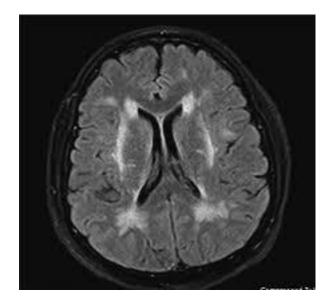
Brain MRI findings in a patient with CADASIL. FLAIR images demonstrate hyperintense lesions in bilateral periventricular and subcortical white matter and bilateral external capsules. In this study, the number of lesions and lesion volume were obtained using the lesion growth algorithm for lesion segmentation.
